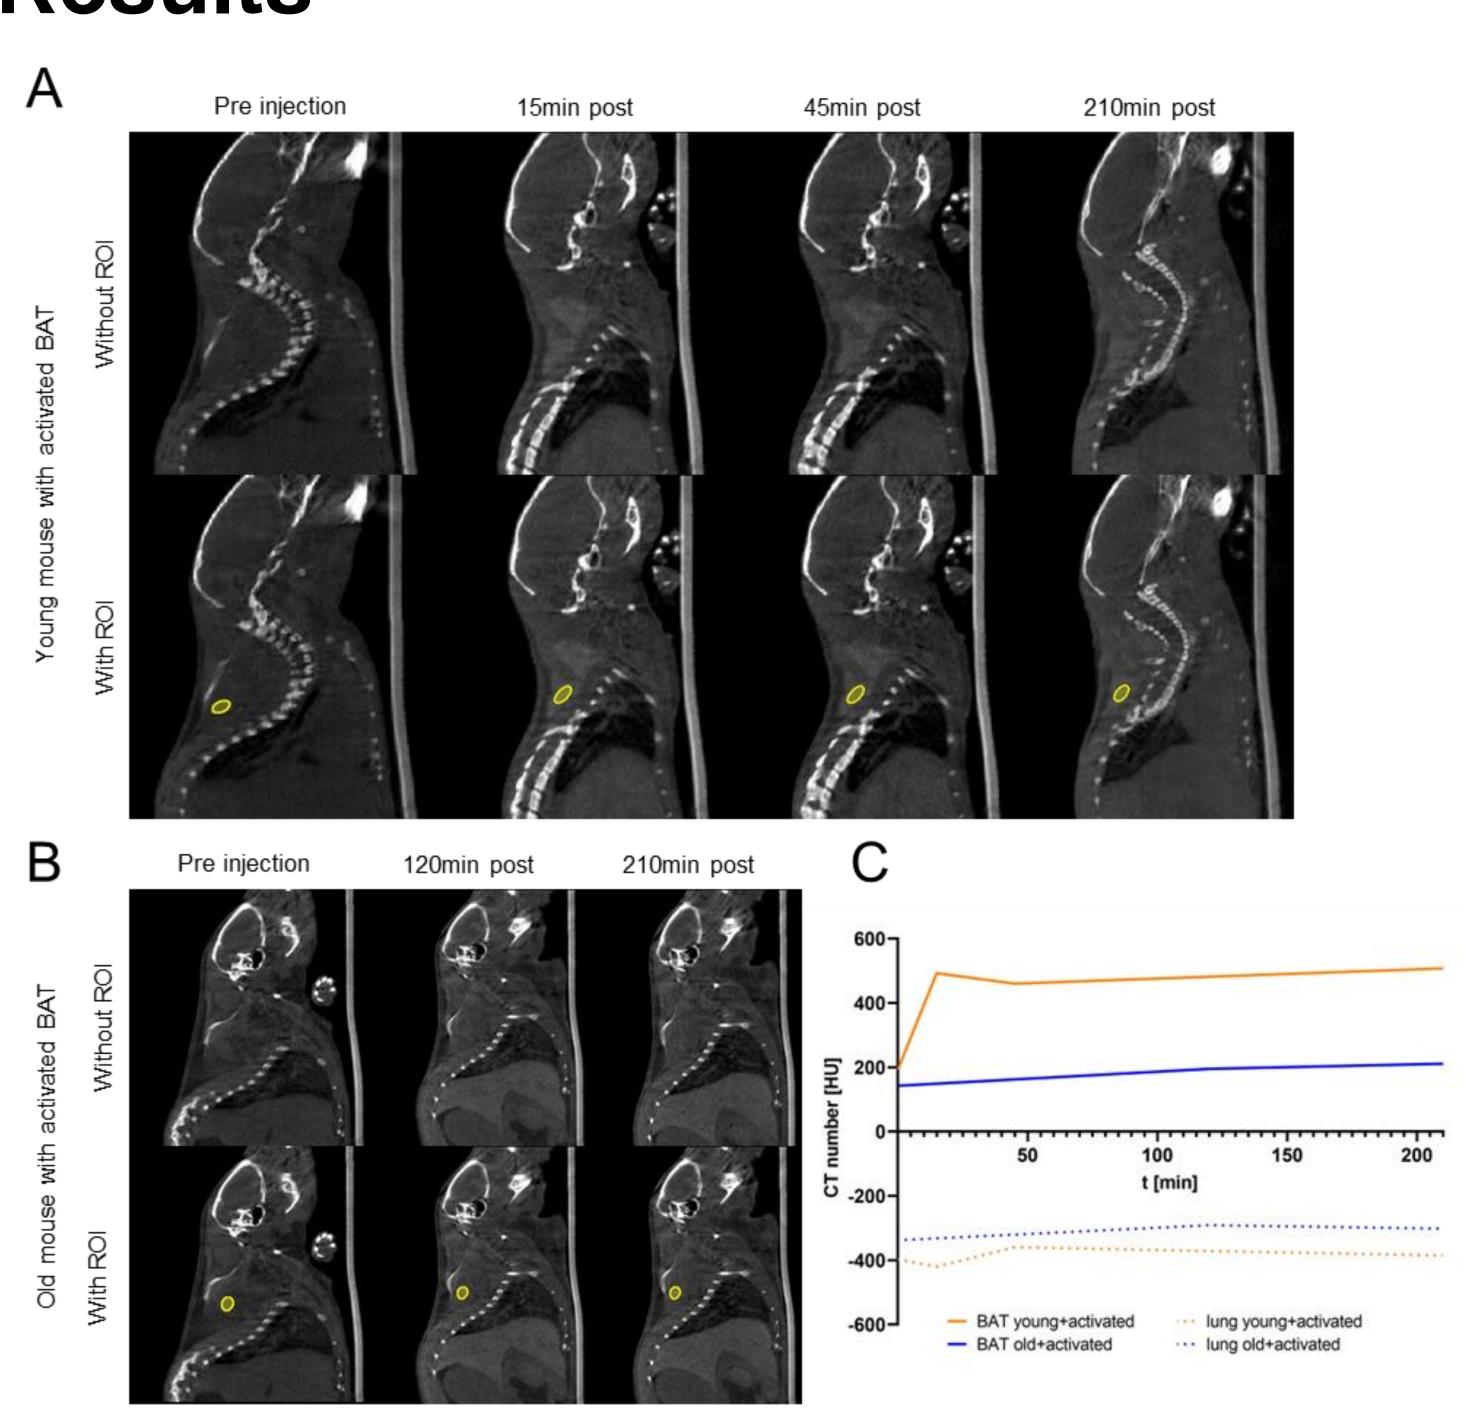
Visualisation of BAT after cold exposure using ExiTron™ BAT and CT imaging
